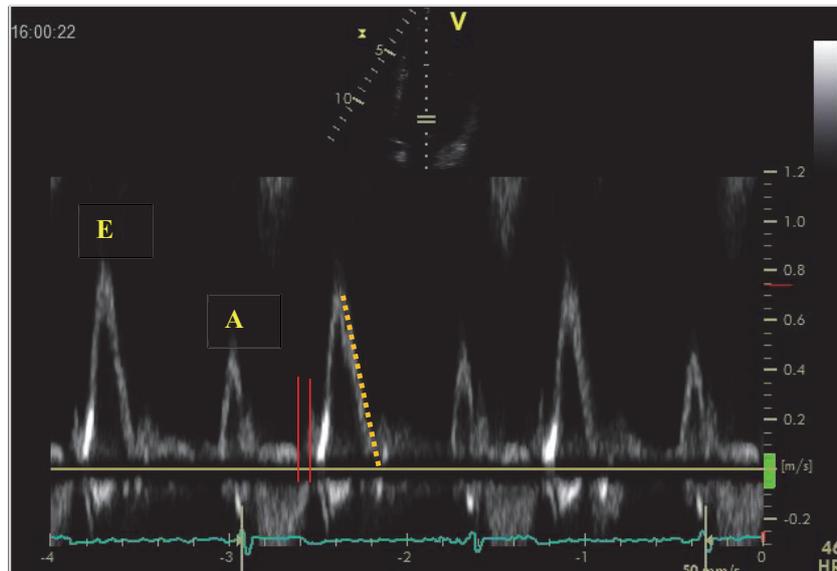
Conventional Doppler echocardiography of the LV mitral inflow velocity in an individual with normal cardiac function. E, peak early diastolic mitral inflow velocity. A, late diastolic mitral inflow velocity (atrial contribution). Red lines represent the time interval of isovolumic relaxation (IVRT). The orange dotted line represents deceleration time (DT)
